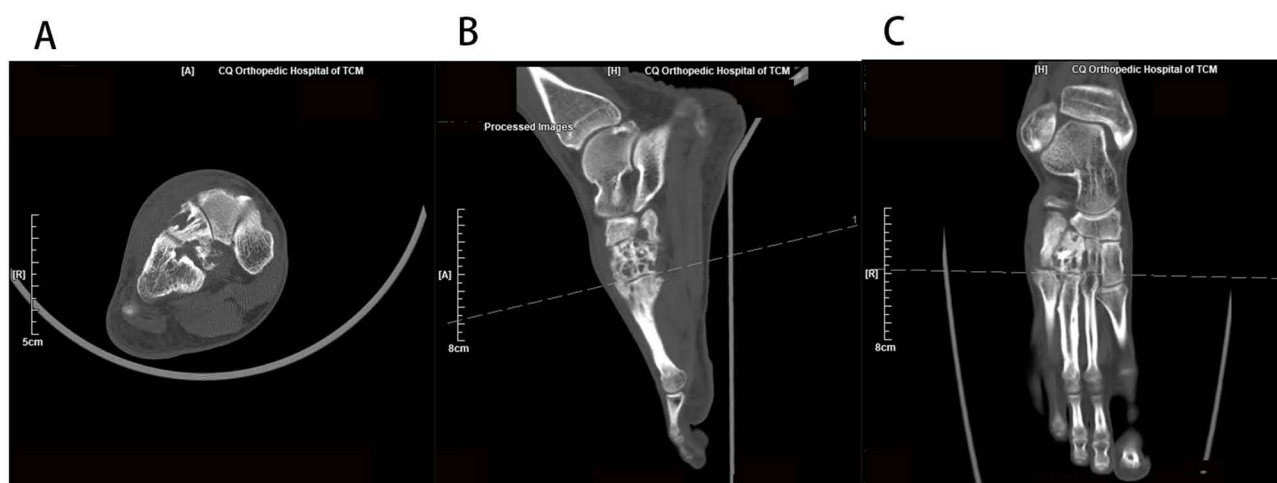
Pre-operative CT. (A) Coronal view, (B) sagittal view, and (C) axial view.
